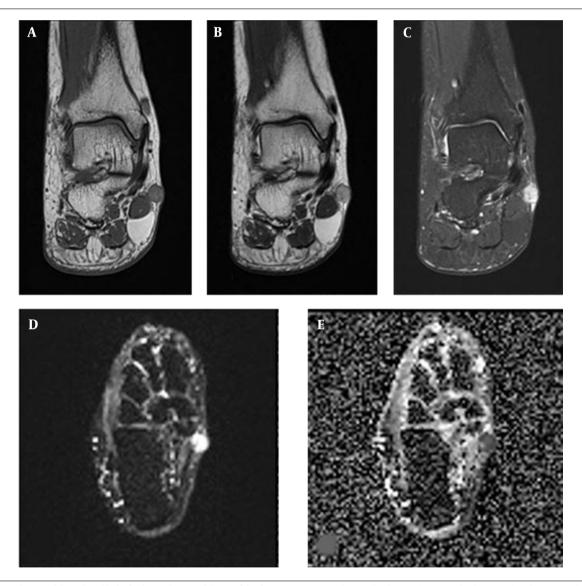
The MRI of the right ankle for further evaluation of the painful soft tissue mass. Coronal TI-weighted image (A), T2-weighted image (B), and contrast-enhanced fat-suppressed TI-weighted image (C), show a t cm, well-defined mass with iso-signal intensity on TI-weighted images and high signal intensity on T2-weighted images. After contrast injection, the lesion shows homogenous enhancement. The high b-value (b = 1000) diffusion-weighted image (D), shows restricted diffusion with a low apparent diffusion coefficient (ADC) (E).
